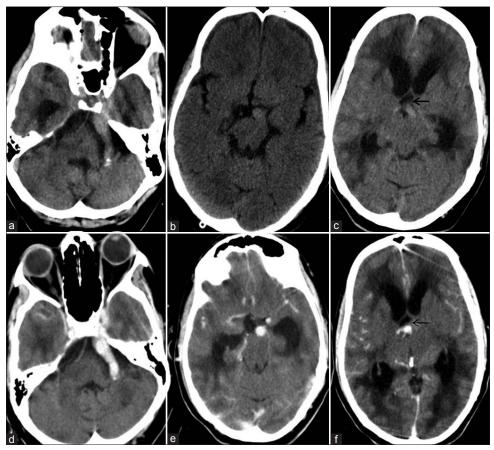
Plain (a–c) and contrast enhanced CT (d–f). Left vertebral artery (a, d) is dolichoectatic. Basilar artery (b, c, e, f), which is also dolichoectatic is compressing the third ventricle, causing dilatation of the anterior third ventricle (arrow) and bilateral lateral ventricles. There is periventricular diffuse hypodensities due to hydrocephalus
